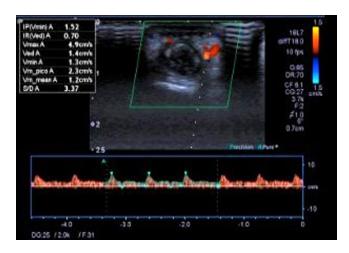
Upper limb Doppler ultrasound showing decreased fluids with parvus tardus waves in the palmar and dorsal digital arteries of the fourth finger of the left hand.
